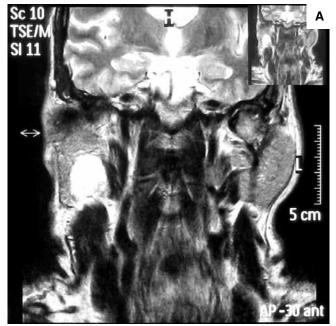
A. T1 weighted MRI scan, coronal section: a 3.5×2.0 cm mass is located in the superficial lobe of the right parotid gland. B. T1 weighted MRI scan, axial section: an oval mass of about 1.0 cm in diameter is located in the left side of the nasopharynx.
